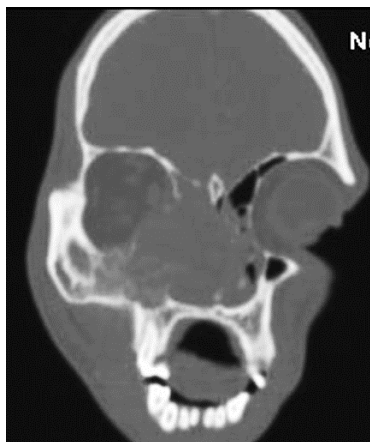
CT PNS showing hypodense lesion occupying Right maxillary and anterior ethmoid sinuses
